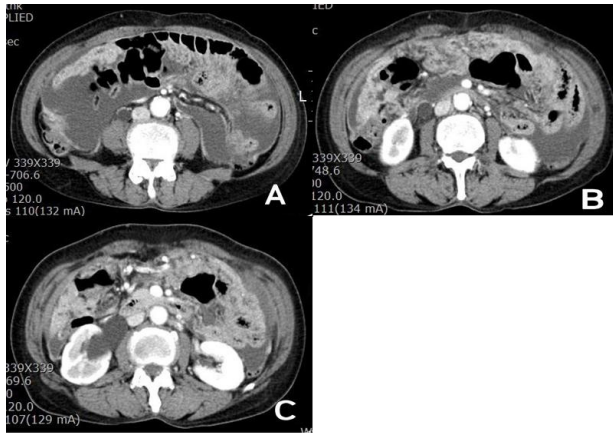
(A, B) Abdominal CT scans showed ascites, peritoneal thickening, omental smudge and cakes consistent with cancer peritonei. (C) Hydronephrotic change at the right kidney also presented. CT: computed tomography.
